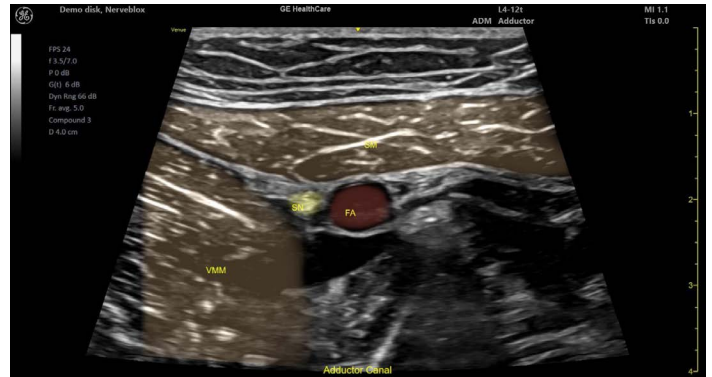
Ultrasound image of adductor nerve block.
